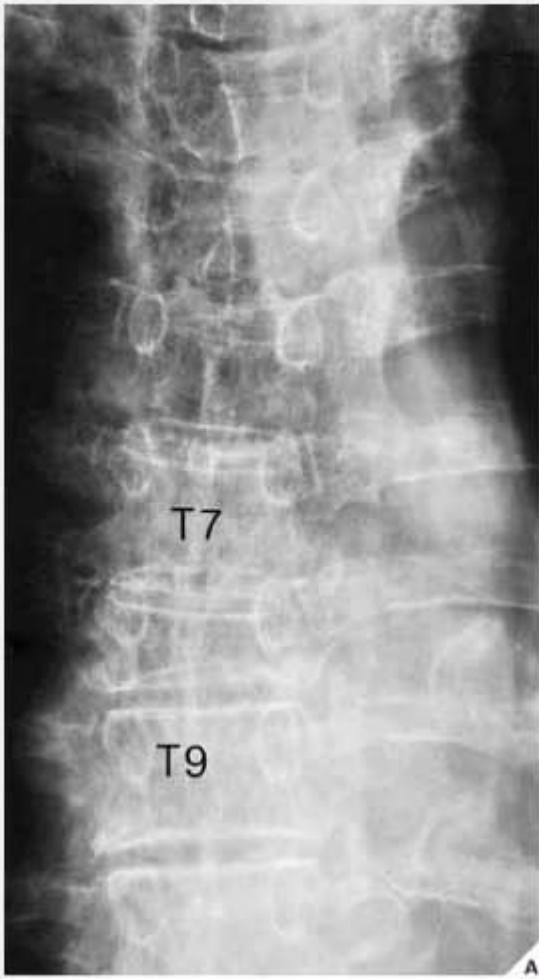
Variants in the radiographic presentation of myeloma.
